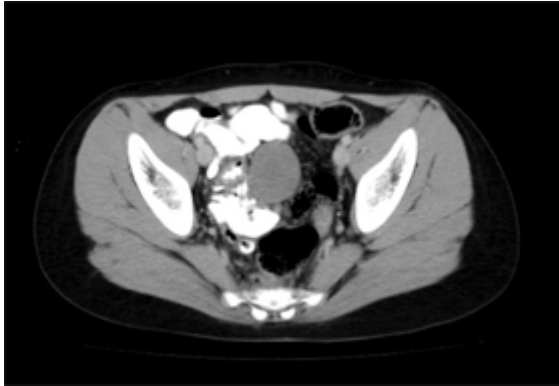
Abdominal CT demonstrates a well-circumscribed, thin-walled cystic mass between intestinal loops.
